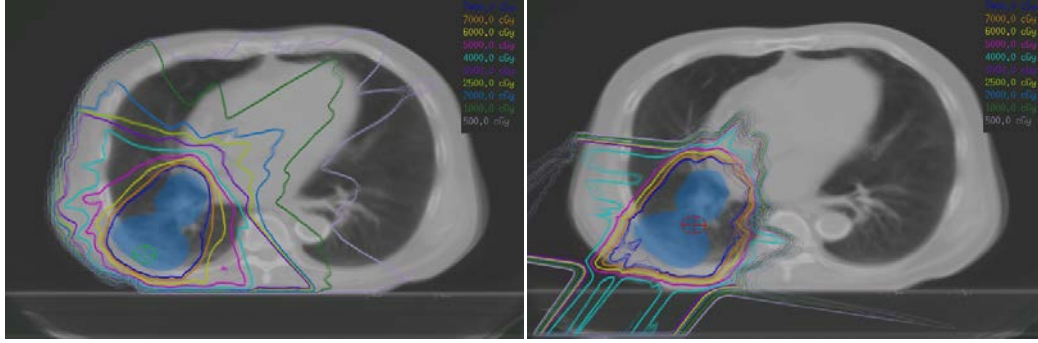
Example of dose variation due to anatomy change between photon and proton beam therapy. Doses due to weekly anatomical motion change overlaid over the original planning CT scan for (left) photon IMRT, and (right) proton PSPT plans. Notice the large amount of dose distribution changes (the blurring of the isodose lines) seen in the distal edges of the proton beam plan compared to the relatively small changes seen in the photon IMRT plan.
